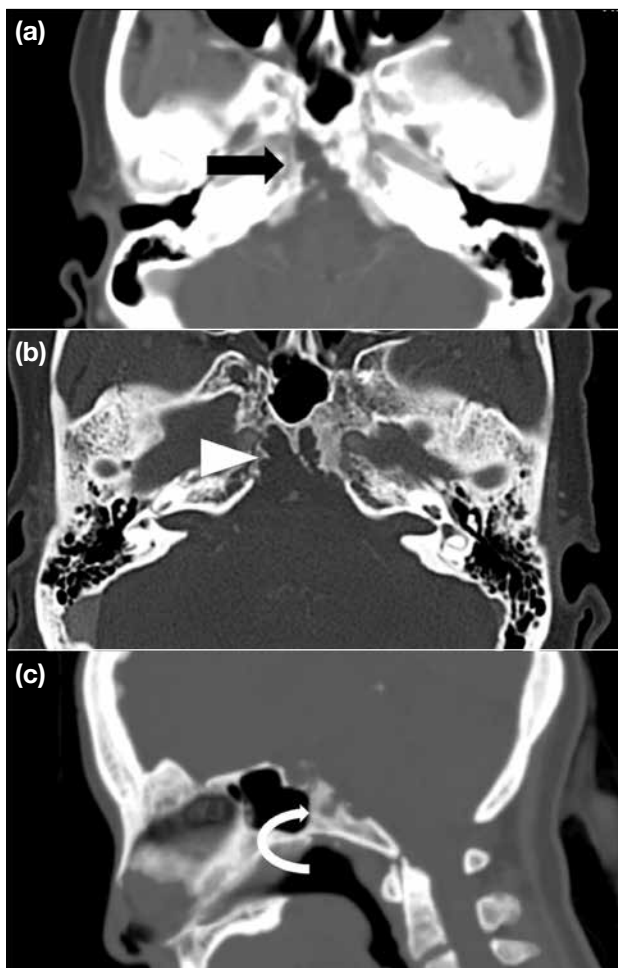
Computed tomography of the brain. (a) There was an isodense lesion with no internal matrix calcification seen extending into the pre-pontine cistern (arrow). It is associated with (b) bony defect (arrowhead) with (c) no visible stalk identified (curve arrow).
